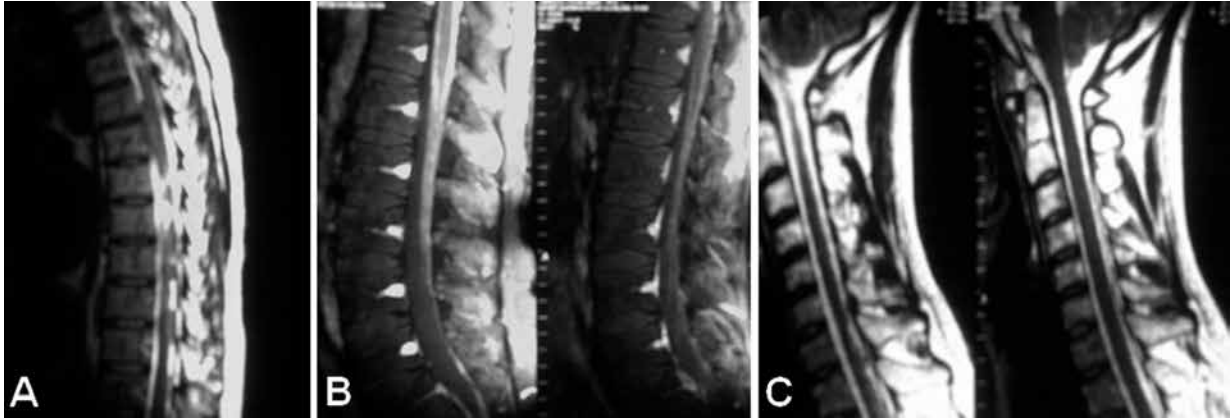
Sagittal neuroaxial T2 MRI, showing multiple lesions in extramedullary intradural space; cervical (A), thoracic (B) and lumbar (C).
